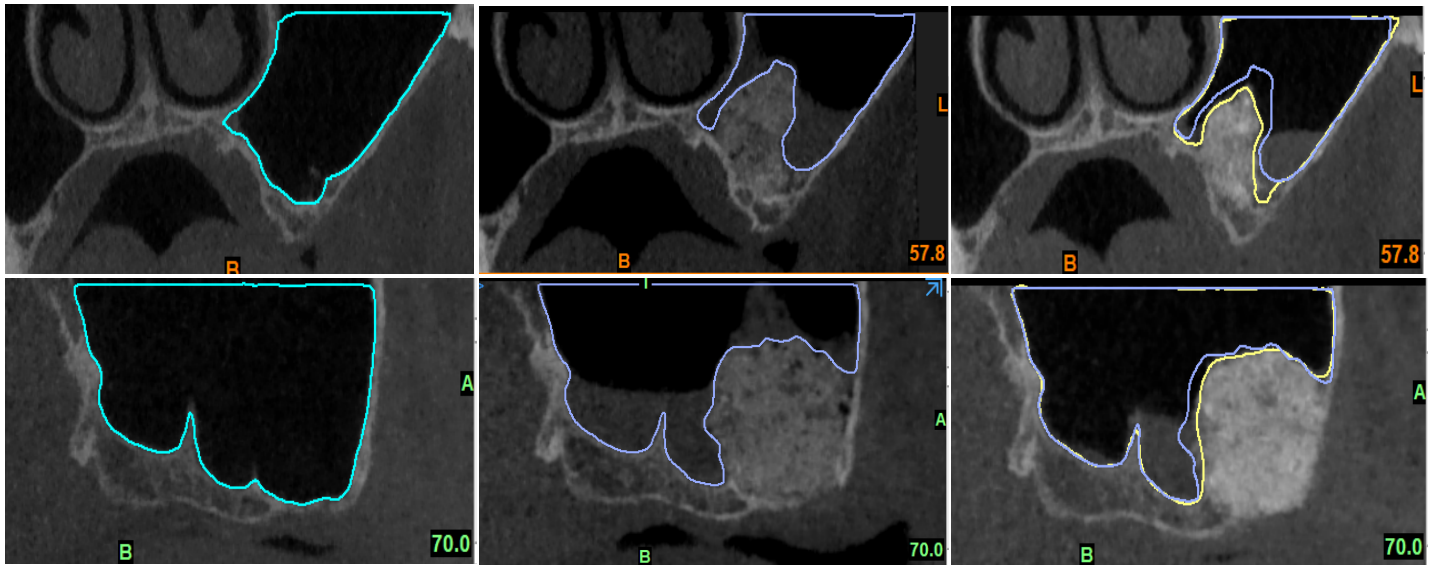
3D maxillary sinus model contours on coronal and sagittal views of cone-beam computed tomographic images. A. preoperative image, B) immediate postoperative view (blue) showing sinus changes represented by bone gain following sinus augmentation, C. superimposed immediate (blue) and 6 months postoperative view (yellow) showing sinus changes represented by bone resorption.
